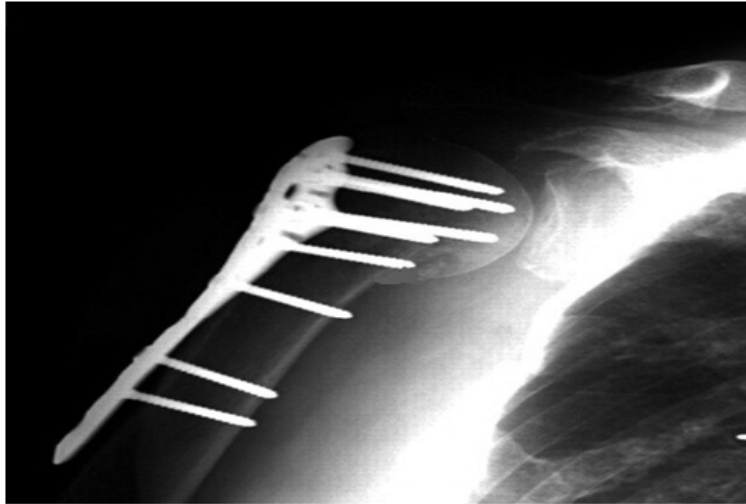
follow up x-ray at 16 weeks revealing fracture union
